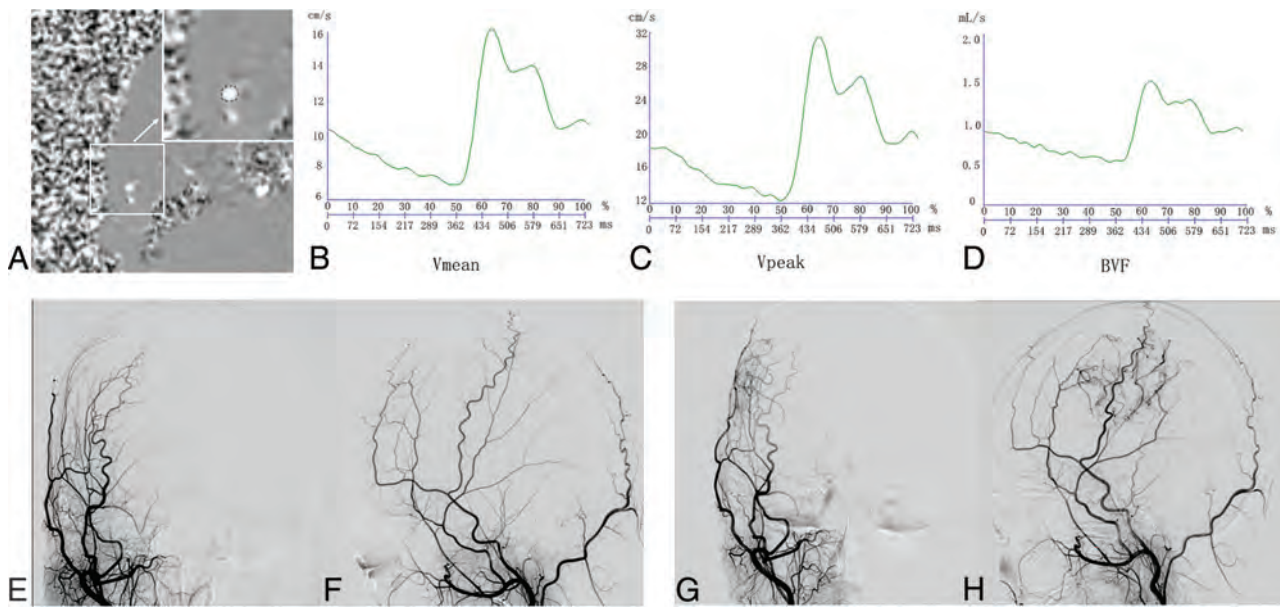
PC-MR imaging and DSA examination in a patient with good collateral formation. Images in a female patient diagnosed with MMD who had right EDAS surgery. She underwent PC-MRI and DSA before and 6 months after the operation. A, Phase image shows the ROI of the right STA. A, the *arrow* represents the enlarged view of the small white square. Modulation of the Vmean (B), Vpeak (C), and BVF (D) of the right STA acquired by PC-MRI. Anterior-posterior and lateral projections of preoperative (E and F) and postoperative (G and H) DSAs of the right external carotid artery show large areas of revascularization (more than one-third but less than two-thirds of MCA territory).
